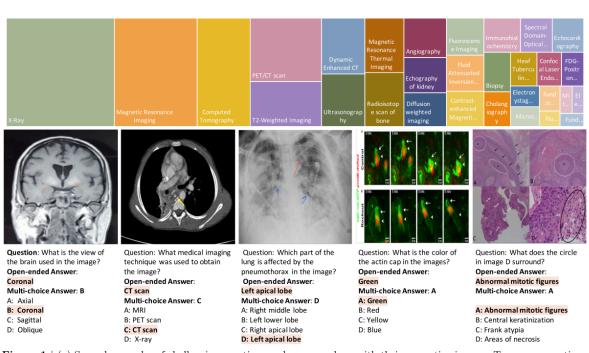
(a) Several examples of challenging questions and answers along with their respective images. To answer questions related to these images, the network must acquire sufficient medical knowledge, for example, for the first two images, it is essential to recognize the anatomy structure and modalities; for the third image, recognizing the X-ray image pattern of pathologies is necessary; for the final two images, apart from the basic biomedical knowledge, the model is also required to discern colors, differentiate subfigures, and perform Optical Character Recognition (OCR). (b) The top 20 figure types in PMC-VQA, cover a wide range of diagnostic procedures.
